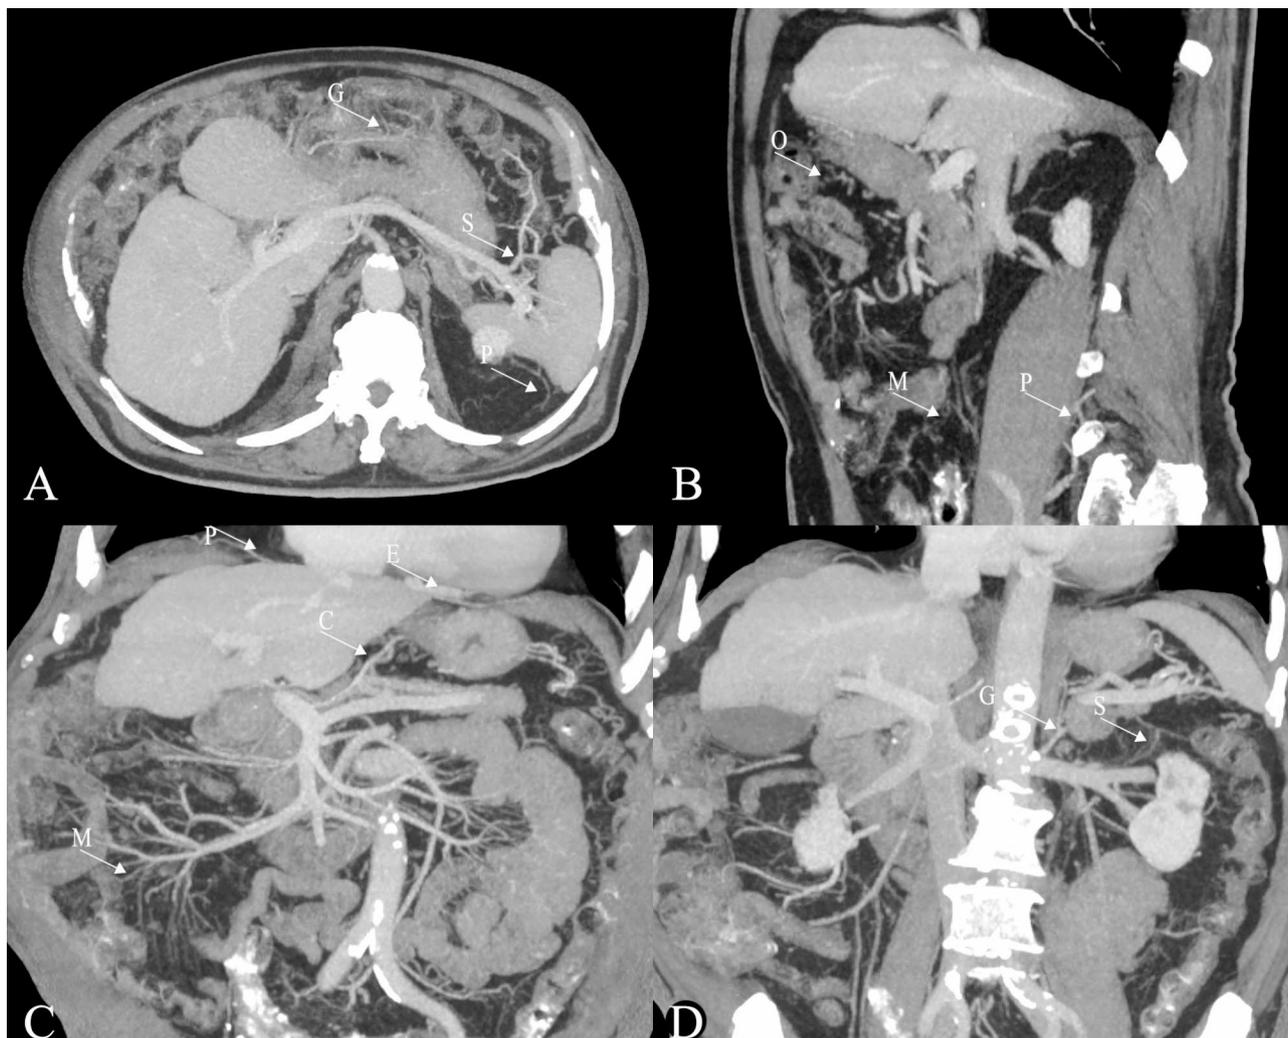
Postcontrast CT and portal vein system reconstruction of an NCPH patient with EGVB. The short gastric vein (S), gastroepiploic vein (G) and perisplenic vein (P) were tortuous on the axle CT image, and no obvious tortuous paraumbilical vein or abdominal wall vein was observed (A). Mild tortuosity of the omental vein (O) paravertebral vein (P) and mesenteric vein (M) is seen on the sagittal CT image (B). Tortuosity of the coronary vein (C), esophageal vein (E), paraesophageal vein (P) and mesenteric vein (M) is seen on the coronal CT image (C). Tortuosity of the splenorenal vein (S) and gastrorenal vein (G) is seen on the coronal CT image (D)
